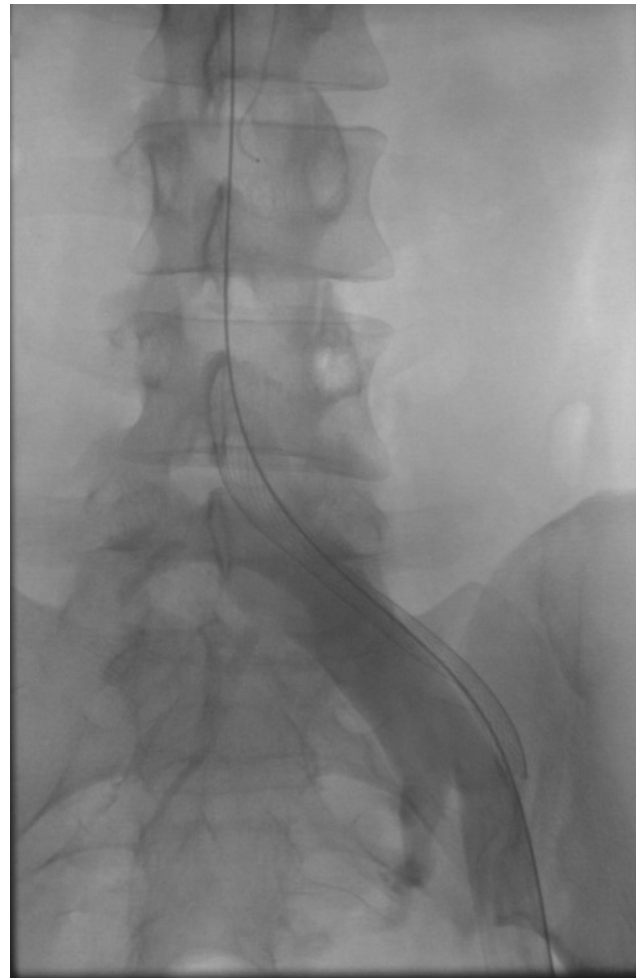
Intraoperative frontal radiograph showing the projection of the stent along the left iliac vein trajectory
